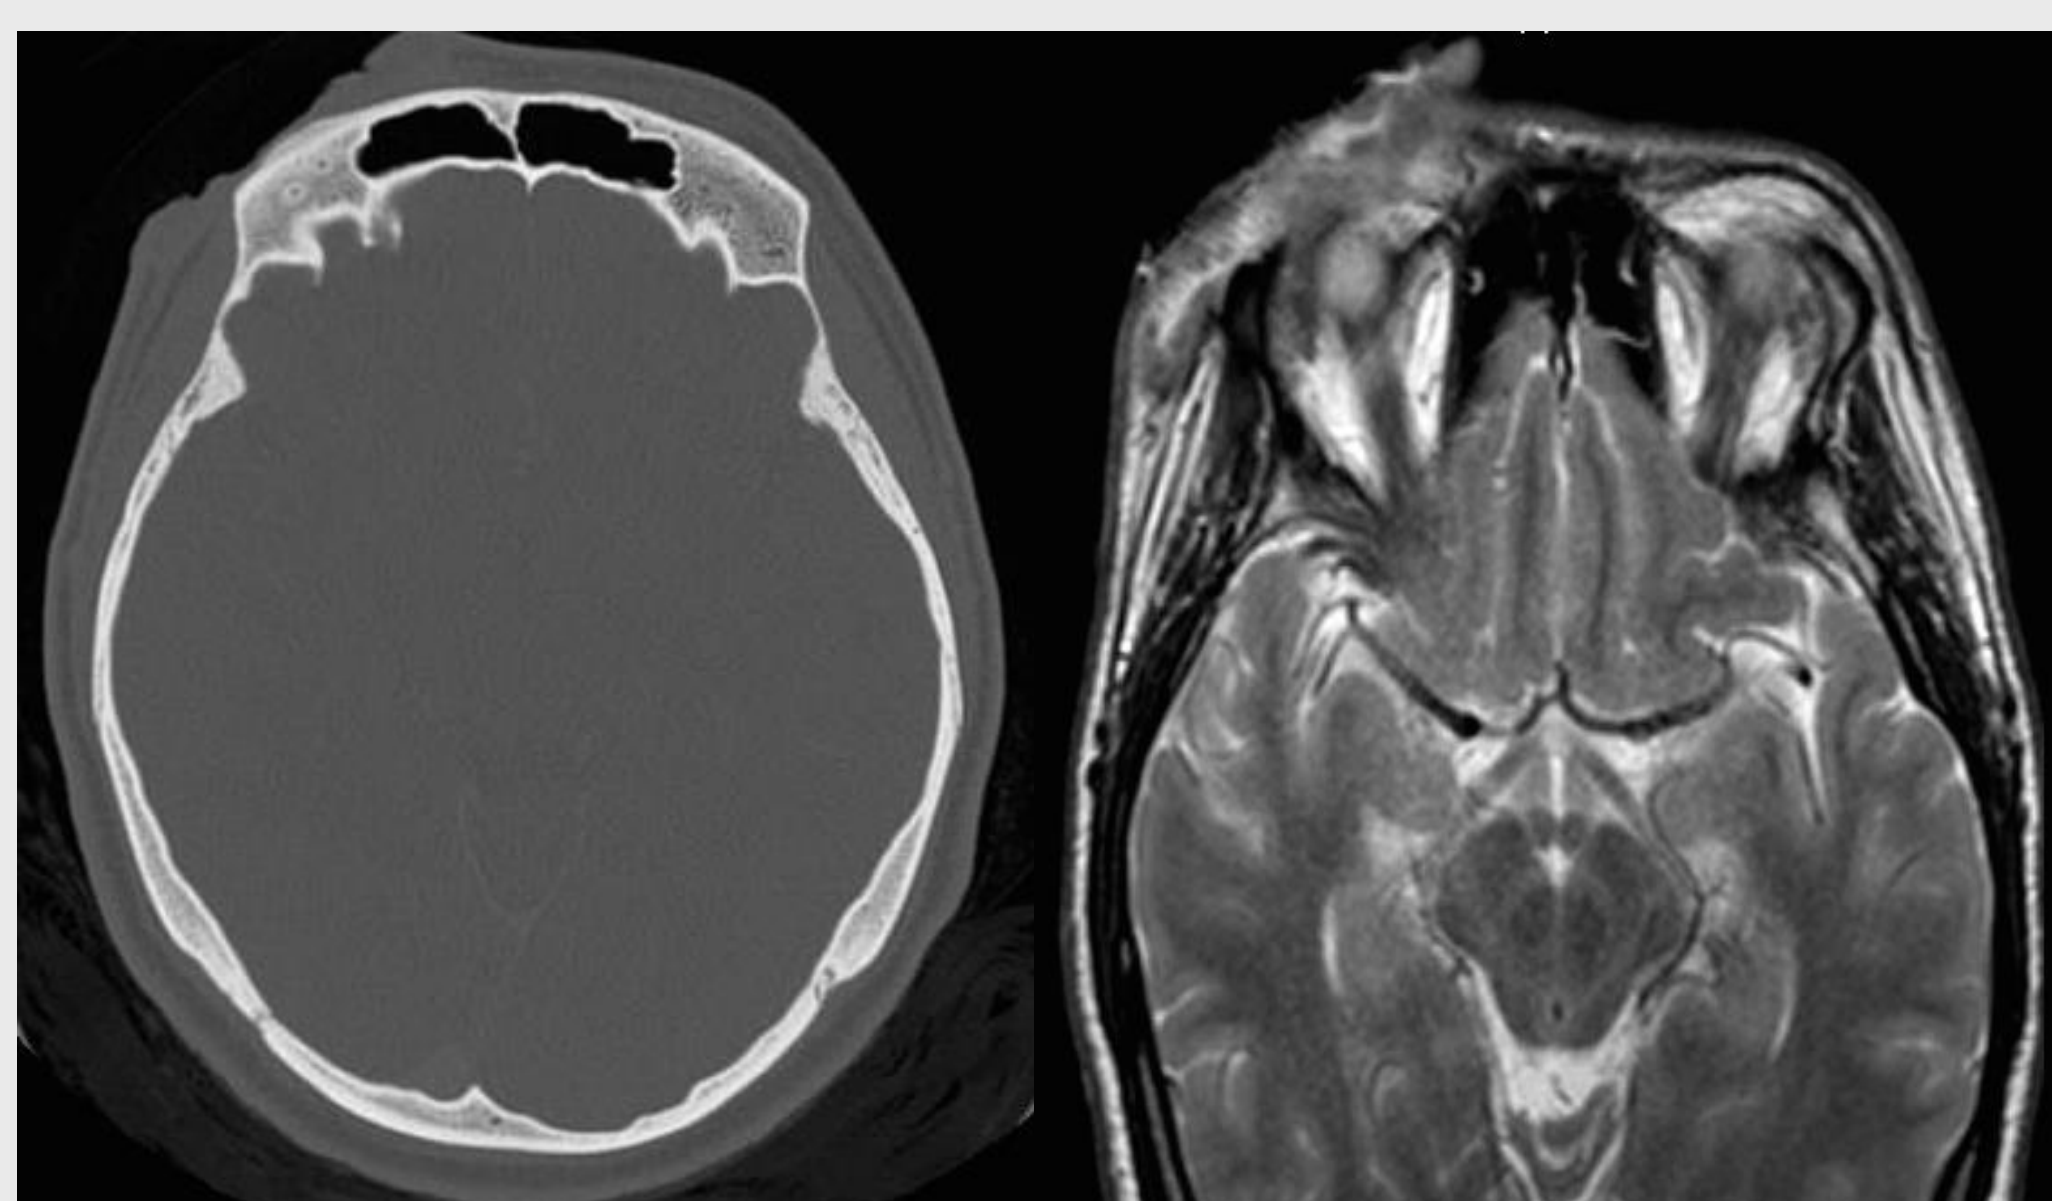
CT (left) showing hyperostosis of right frontal bone. MRI (left) showing extension of lesion into right eyelid.
